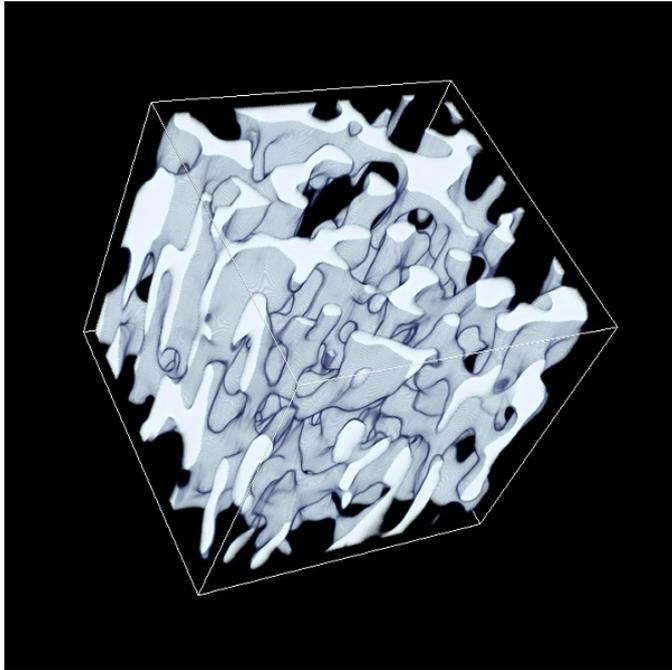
Volume rendering of trabecular bone extracted from MRI images of the distal radius of a normal subject.
